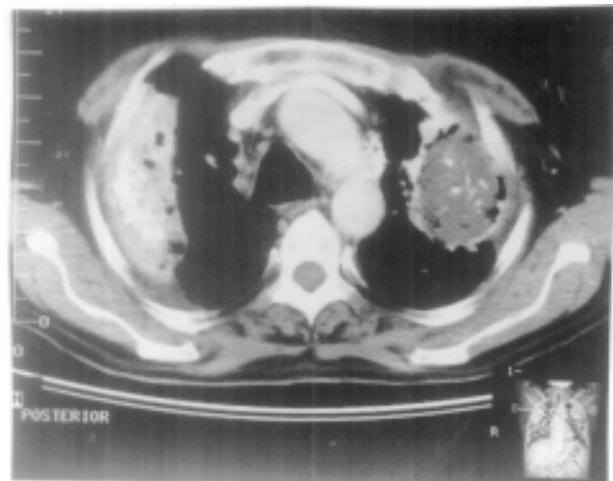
Contrast-enhanced computed tomogram of the thorax showing PMF in the right lung with areas of breakdown and calcifications. A mass like lesion with areas of calcification is seen within the cavity in the left upper lobe. The mass is adherent to the irregular margins of the cavity.
